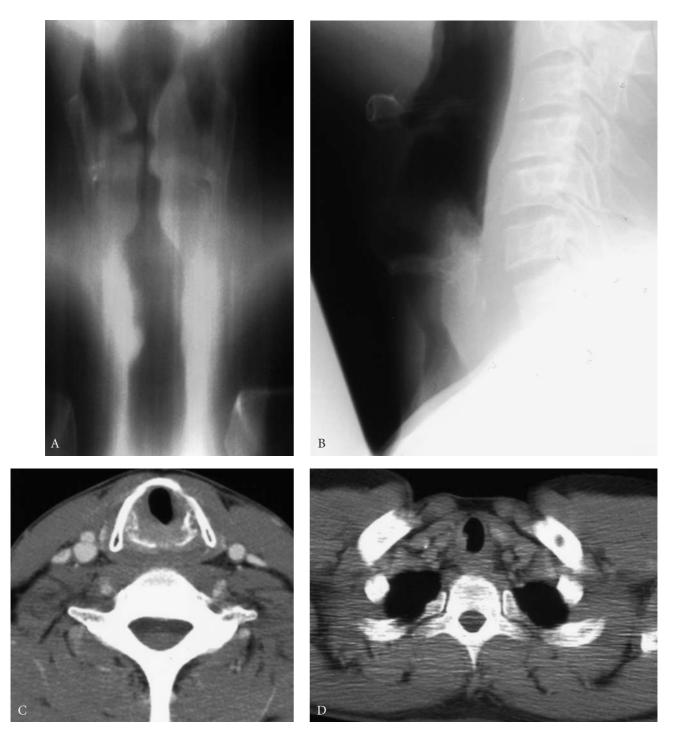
Adenoid cystic carcinoma of the larynx and trachea. Anteroposterior (A) and lateral (B) tomograms of the larynx and proximal trachea and computed tomography scans at the level of the hyoid bone (C) and proximal trachea (D) reveal a smooth nodular tumor with endophytic growth.
